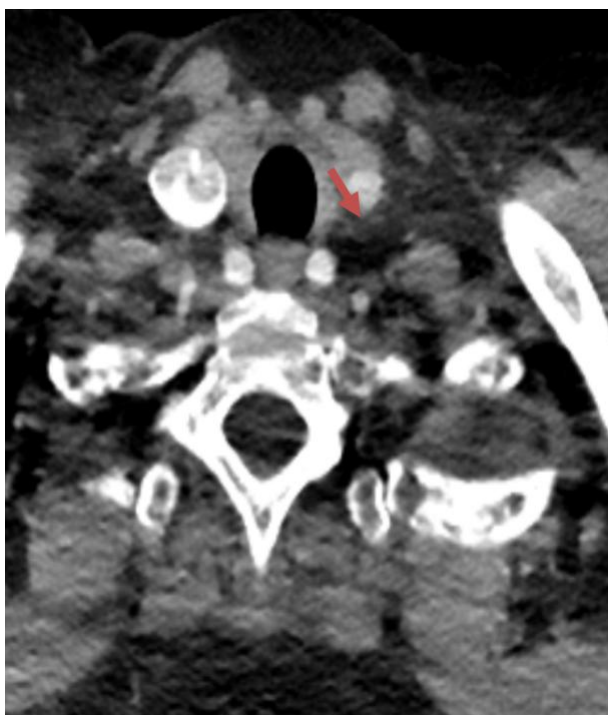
An axial section of a CT scan in 2017 showing a complete resolution of lymph node metastasis (arrow).
